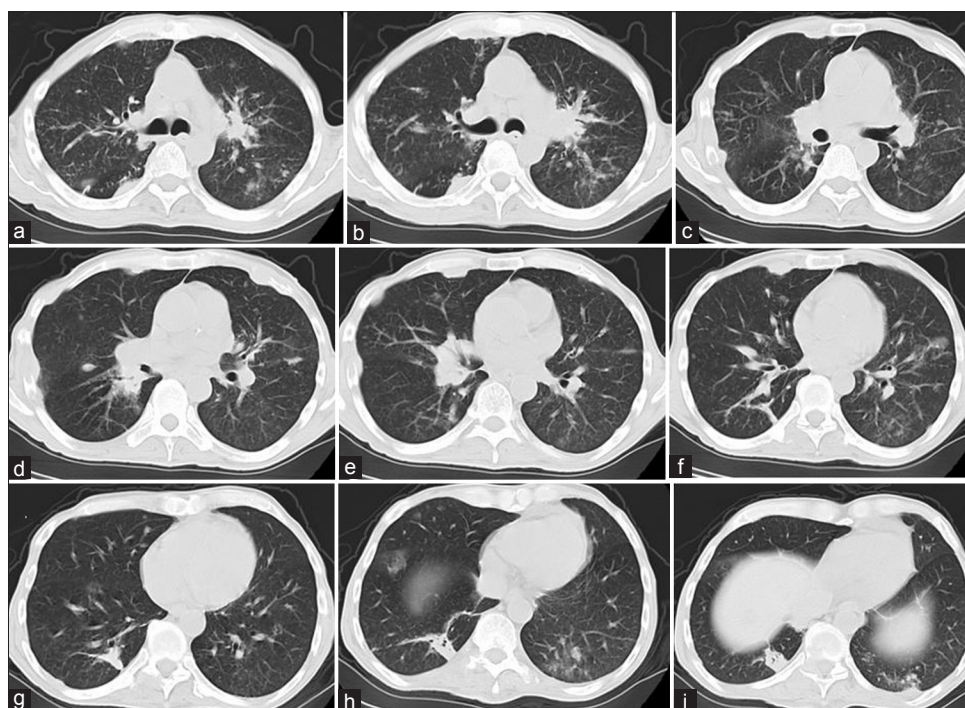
Transverse reconstruction of chest computed tomography scan: Showing bilateral multiple pulmonary nodules
